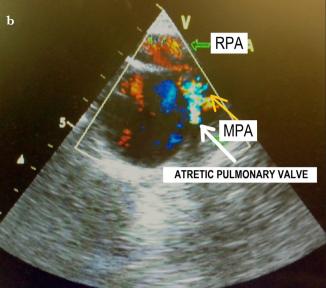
a, b. (a) Upper oesophageal ascending aorta short axis view showing well-formed RPA (RPA: right pulmonary artery, green open arrow); (b): upper oesophageal ascending aorta short axis view with colour Doppler showing atretic pulmonic valve and proximal MPA, with trivial turbulent flow across atretic pulmonic valve and good flow across RPA MPA: main pulmonary artery, yellow solid arrow; atretic pulmonary valve, white solid arrow
